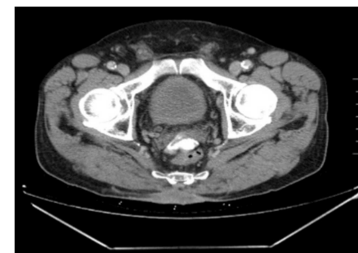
Contrast thoraco-abdominal-pelvic CT where it is appreciated the lesion previously described.
